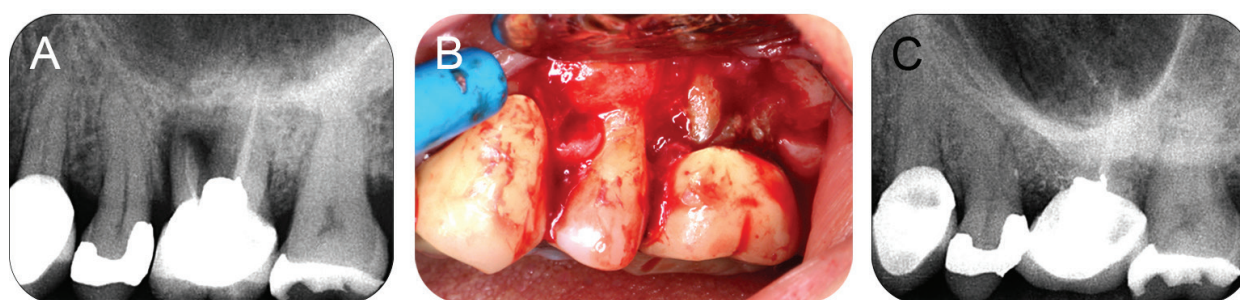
Periodontal surgical management of an upper left first molar with a root fracture. (A) Radiograph of root treated 26 with suspected mesio-buccal root fracture; (B) intra-operative view of 26 confirming initial diagnosis; (C) 26 MB root was resected and the defect regenerated with xenograft and a collagen barrier membrane. Radiograph taken at 6 months post treatment.
